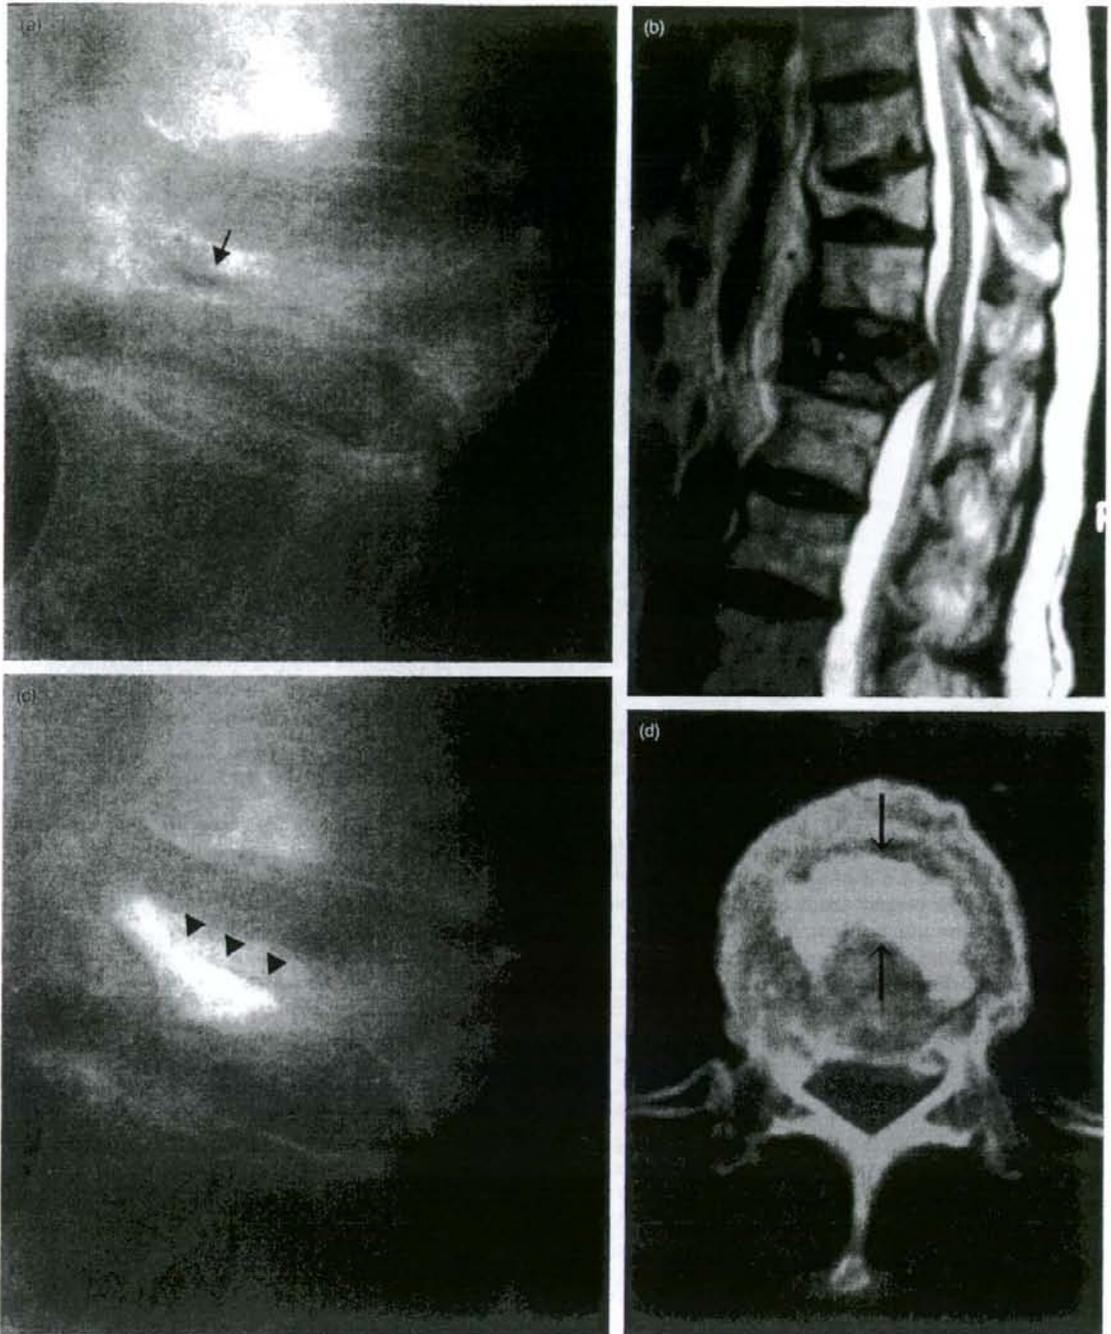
Case 10. (a) Preoperative lateral view of the first lumbar vertebral body. Arrow shows vacuum cleft which reduced in neutral position. (b) Preoperative magnetic resonance image. T2 weighted image shows the unhealed burst fracture of the first lumbar vertebral body and the healed fracture of the 11th thoracic vertebral body. (c) Postoperative lateral view of the first lumbar vertebral body. Arrowheads show the bone cement injected into the vacuum cleft which spread in intraoperative extended position. (d) Postoperative computed tomography of the first lumbar vertebral body. Arrows show the bone cement injected.
